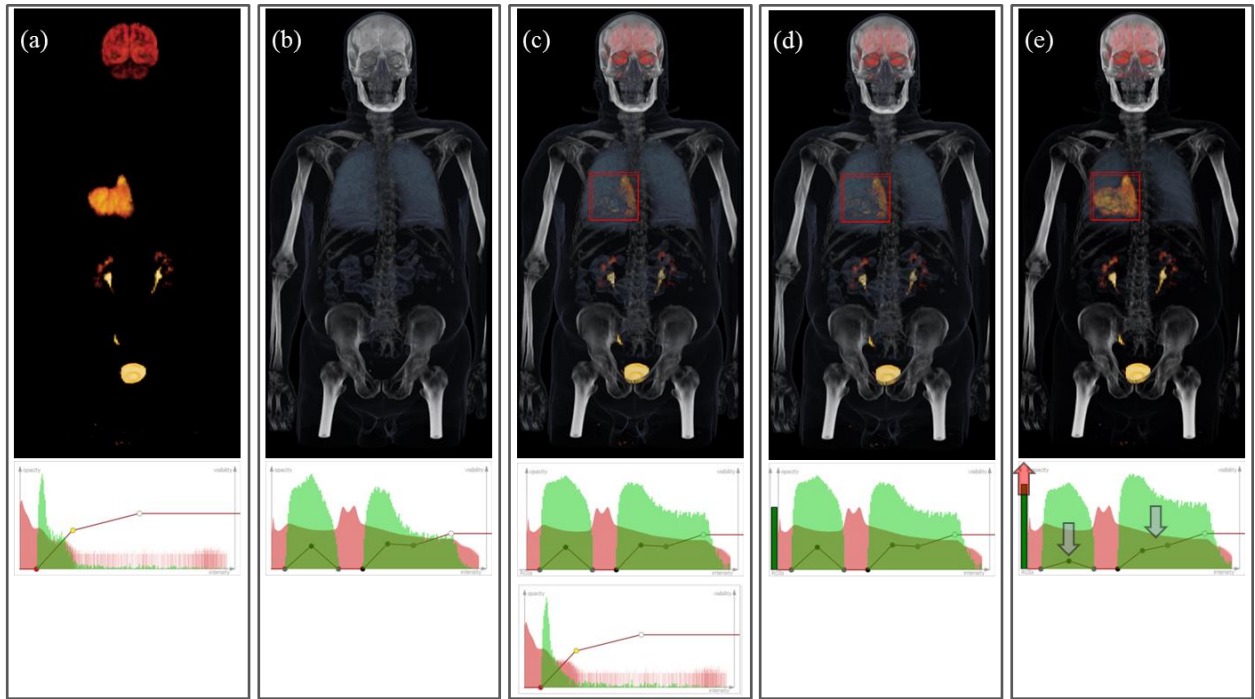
A comparison of PET-CT visualisations between using a pair of single-modal visibility-driven transfer functions ((a) and (b)) and with m^2 -vtf on a PET-CT study ((c) to (e)), with a large high-grade lung tumour patient study.
